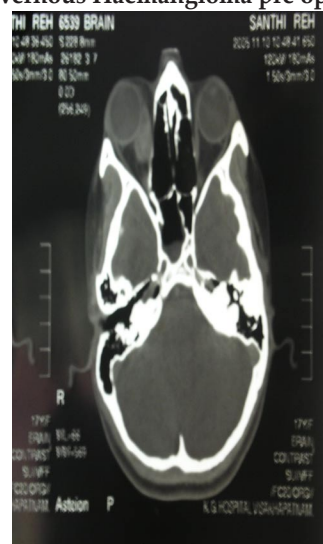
CT – Scan findings:
